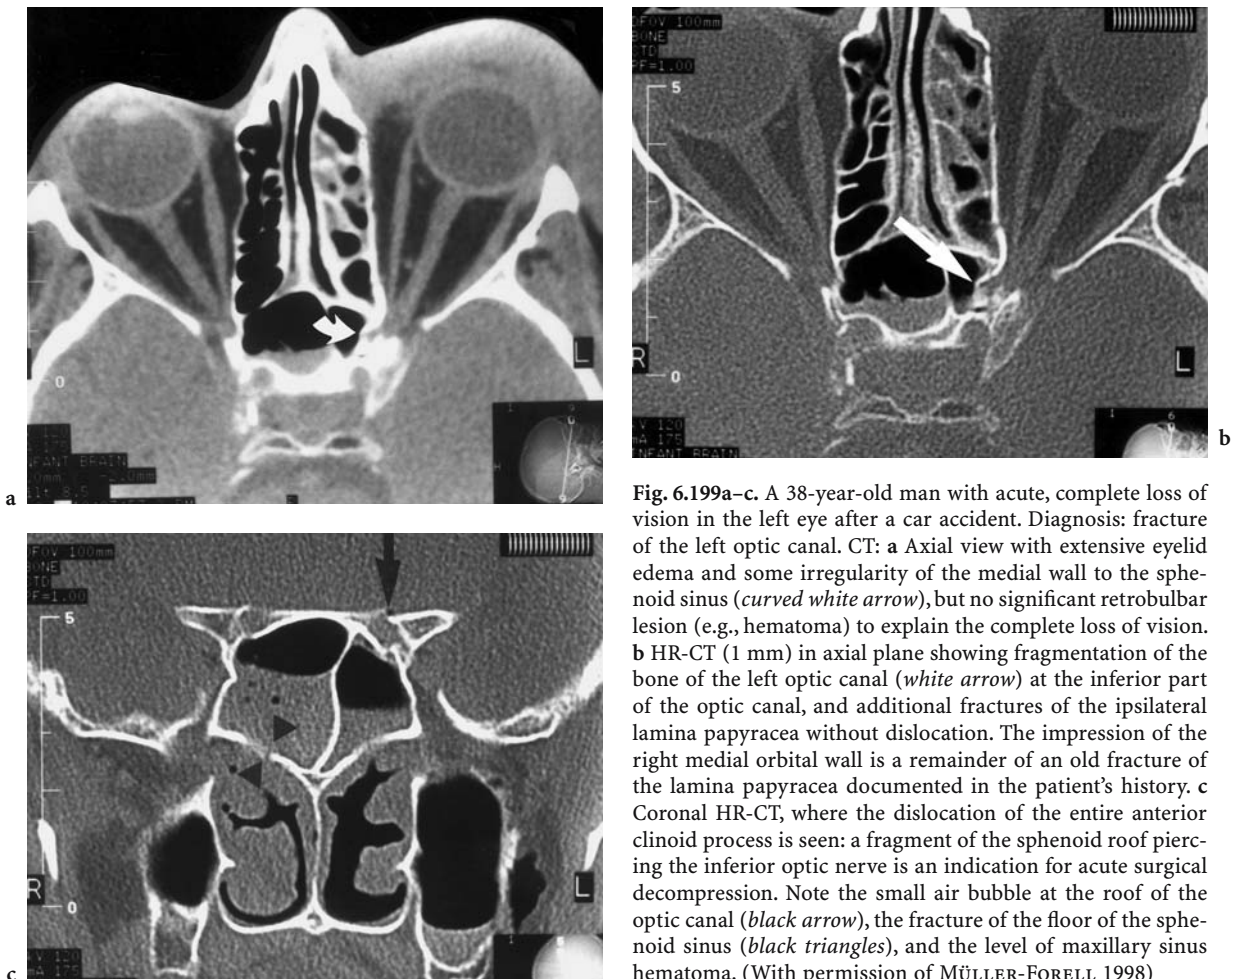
A 38-year-old man with acute, complete loss of vision in the left eye after a car accident. Diagnosis: fracture of the left optic canal. CT: a Axial view with extensive eyelid edema and some irregularity of the medial wall to the sphenoid sinus (*curved white arrow*), but no significant retrobulbar lesion (e.g., hematoma) to explain the complete loss of vision. b HR-CT (1 mm) in axial plane showing fragmentation of the bone of the left optic canal (*white arrow*) at the inferior part of the optic canal, and additional fractures of the ipsilateral lamina papyracea without dislocation. The impression of the right medial orbital wall is a remainder of an old fracture of the lamina papyracea documented in the patient's history. c Coronal HR-CT, where the dislocation of the entire anterior clinoid process is seen: a fragment of the sphenoid roof piercing the inferior optic nerve is an indication for acute surgical decompression. Note the small air bubble at the roof of the optic canal (*black arrow*), the fracture of the floor of the sphenoid sinus (*black triangles*), and the level of maxillary sinus hematoma. (With permission of MÜLLER-FORELL 1998)
